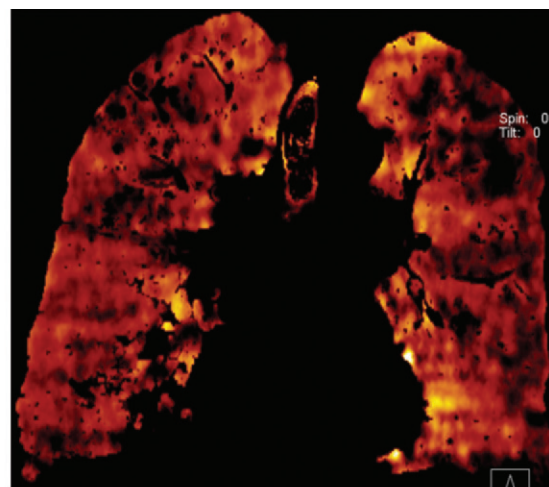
Pulmonary embolism follow-up and risk for progression to CTEPH in two patients. (a, b) A 45-year-old woman who presented with acute shortness of breath. (a) Coronal fused PBV image obtained at presentation shows bilateral emboli (arrows) with corresponding perfusion defects (arrowheads). However, the overall perfusion-defect volume is not large, and no right ventricular dysfunction was seen at echocardiography. (b) Coronal fused PBV image obtained after 4 months of anticoagulation therapy (without thrombolysis) shows resolution of the clots and normal lung perfusion. (c, d) A 67-year-old woman who presented with collapse. (c) Coronal fused PBV image obtained at presentation shows a large occlusive thrombus in the right main pulmonary artery, with marked patchy reduced perfusion in the right lung and a smaller wedge-shaped defect in the left upper lobe (arrowheads). Despite anticoagulation therapy and thrombolysis, the patient had progressive symptoms of right heart failure, with raised pulmonary artery pressure seen at echocardiography. (d) Coronal fused PBV image obtained 7 months later confirms clinical progression and shows features of CTEPH, with clot retraction (arrow) and large residual perfusion defects.
